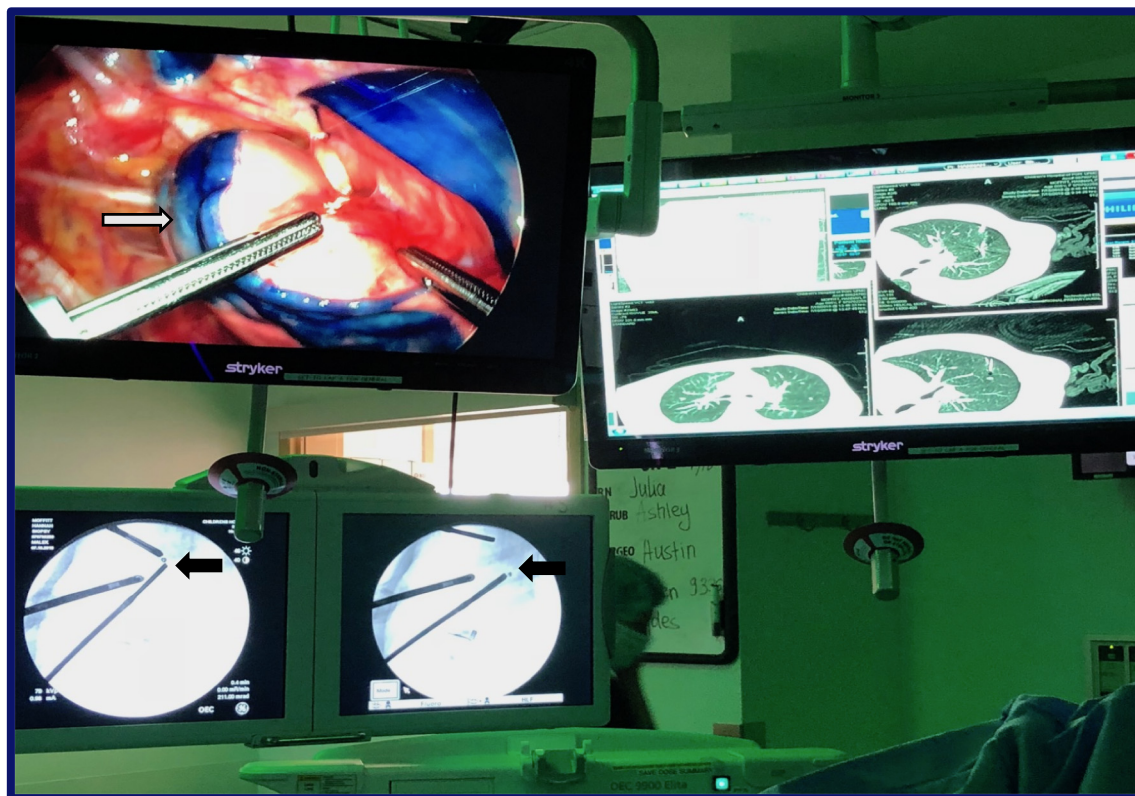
Intraoperative localization utilizing methylene blue dye and microcoils. The CT scan obtained during microcoil placement, thoracoscopy, and intraoperative fluoroscopy are all utilized during intraoperative lesion identification. Methylene blue dye (white arrow) directs the surgeon to the general area of the nodule. Two instruments are used to triangulate the microcoil, which is confirmed on fluoroscopy (black arrows).
